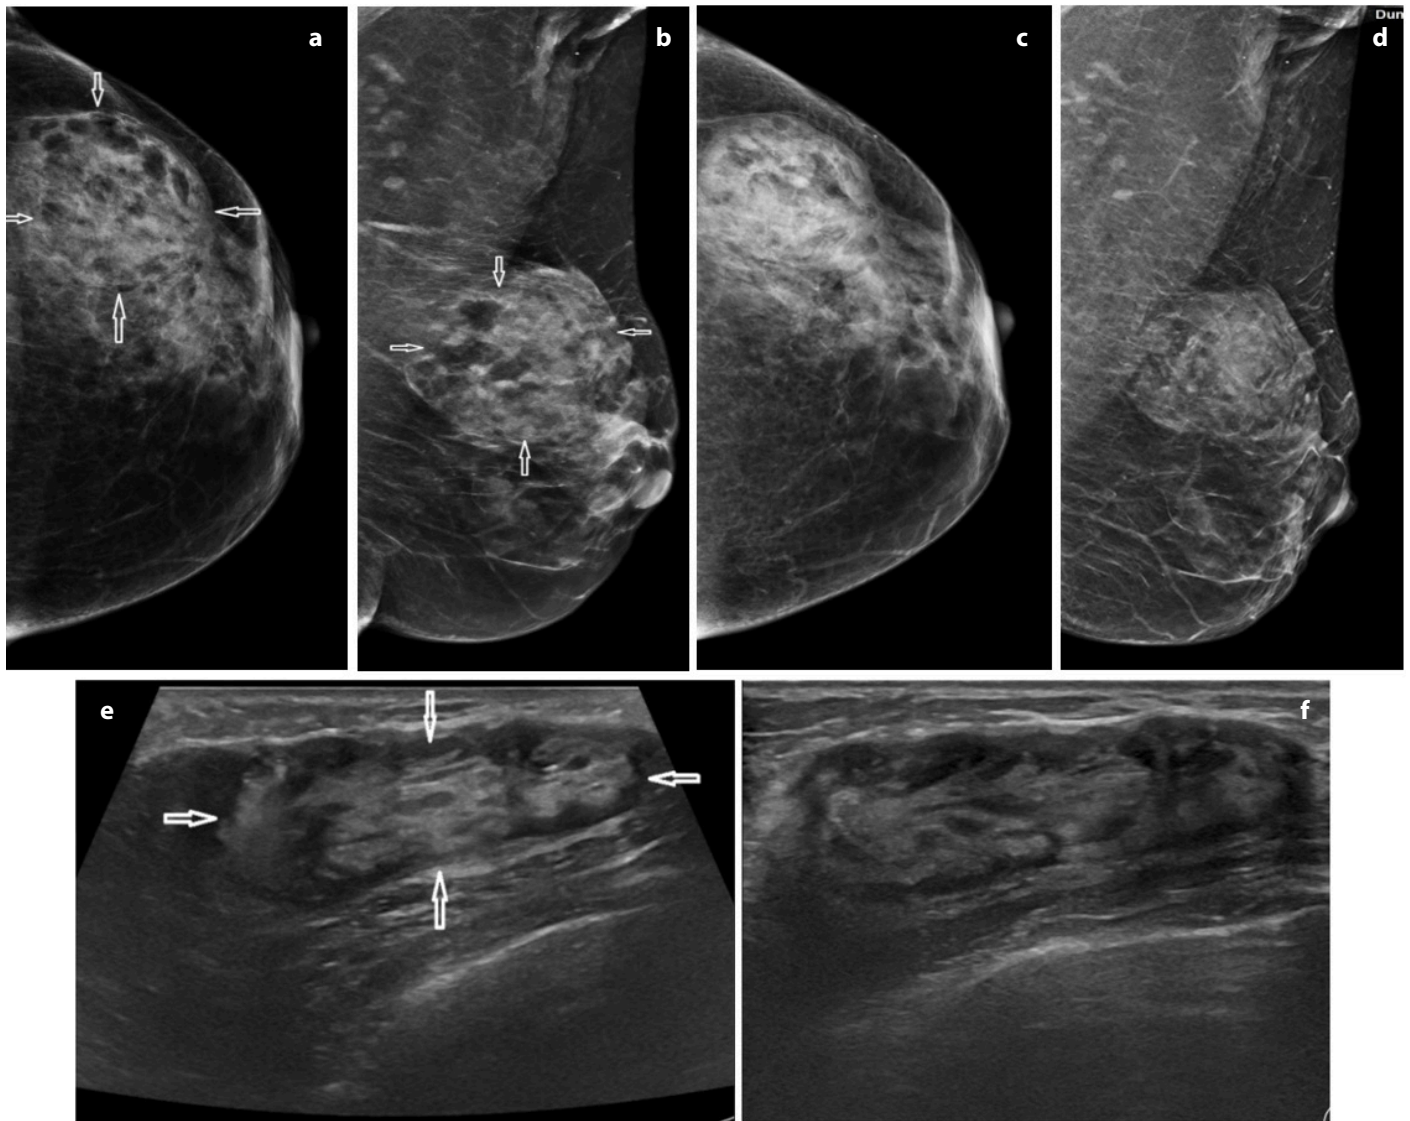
(a-f) Mammography and US images of a 54-year-old patient treated with IORT: initial mammograms (a, b) show a heterogeneous mass (arrows) in the left breast, which persists without any change on follow-up mammograms (c, d) taken three years after therapy. Initial US image of the same patient (e) shows a heterogeneous oval circumscribed mass (arrows). This lesion also persists three years after therapy (f). IORT, intraoperative radiotherapy; US, ultrasound.
